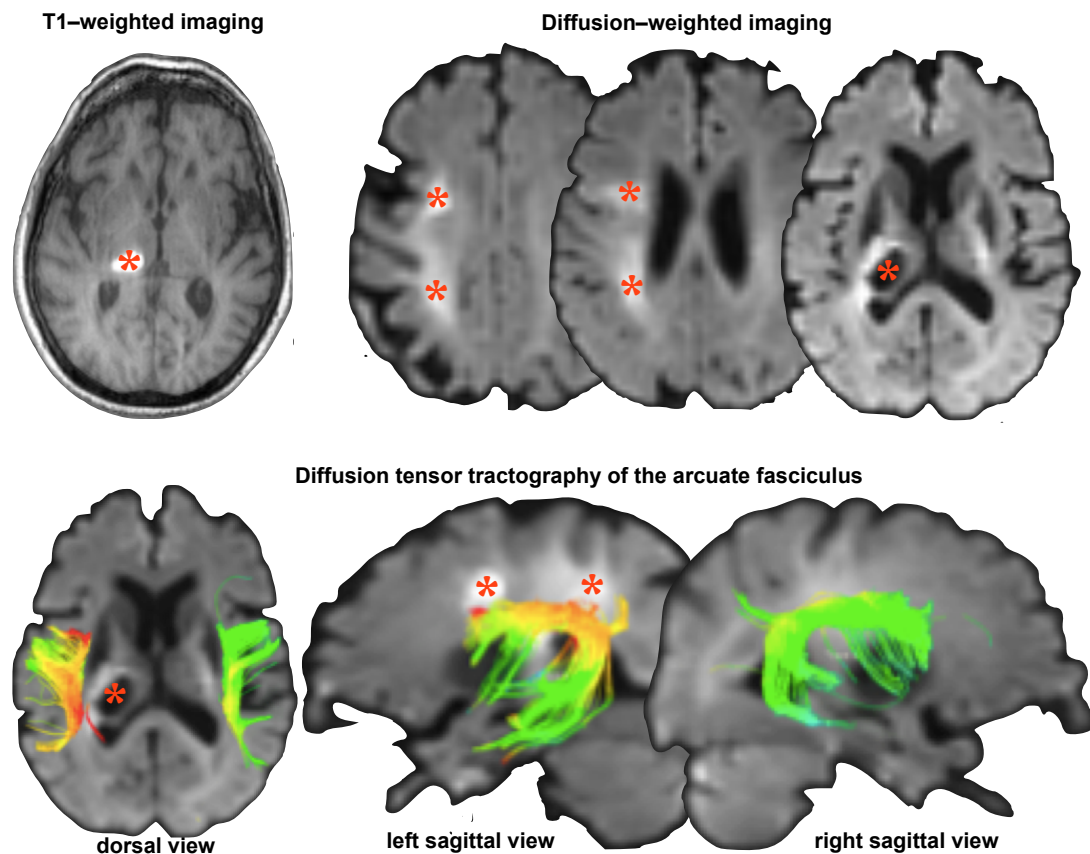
MRI contrasts for patient 01 and the bilateral arcuate anatomy
